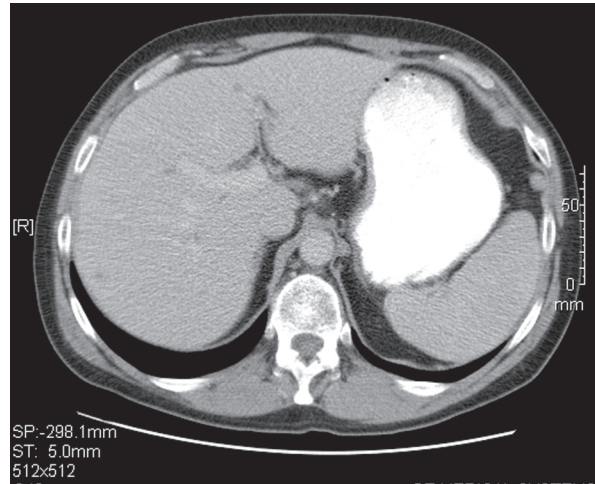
CT scan of the abdomen showing response to the combination of gemcitabine and irinotecan.
